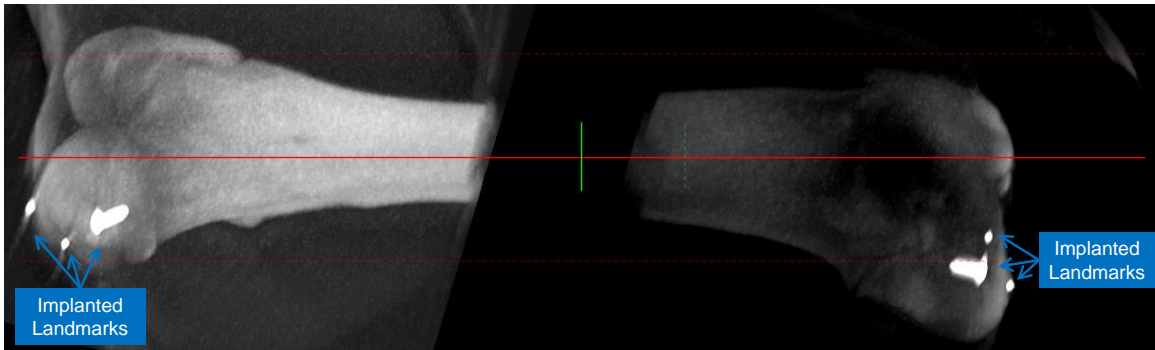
Parallel projection through both CBCT volumes to create a DRR-like visualization.
